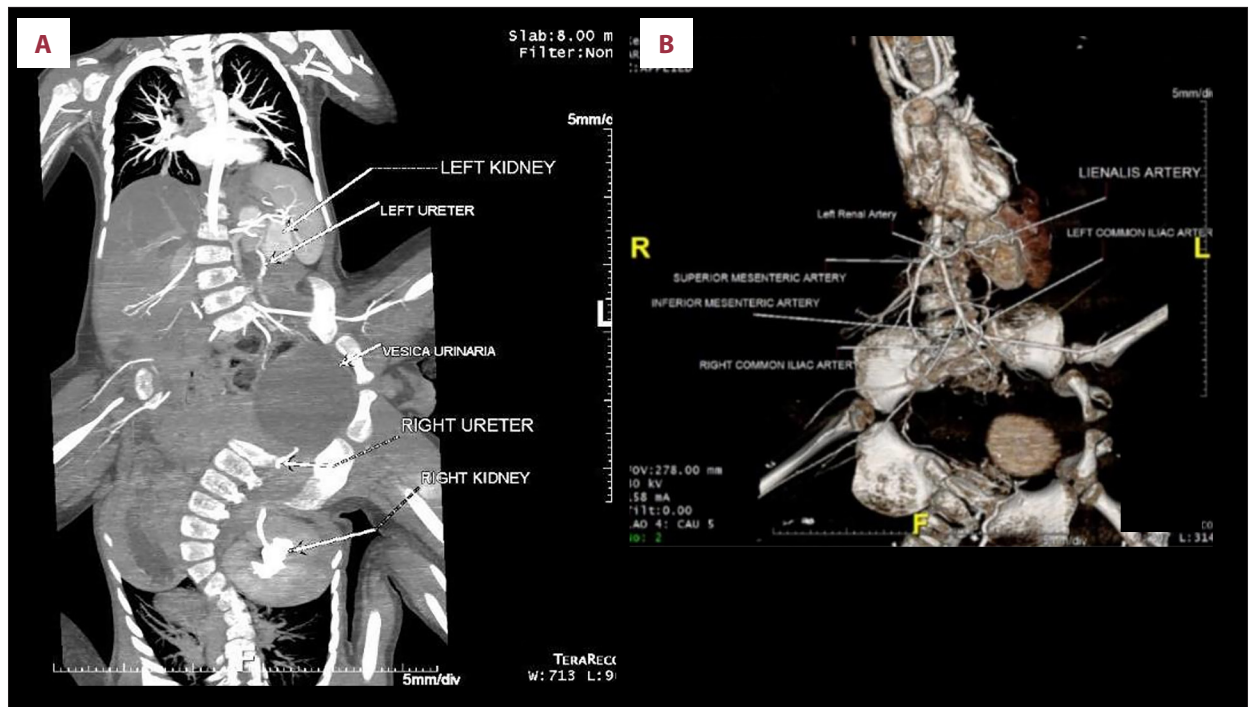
Angiography computed tomography scan of the patient. (A) Left kidney hypoplasia in twin I, and left kidney agenesis in conjoined twin II. (B) Left renal artery appears smaller than the right renal artery.
